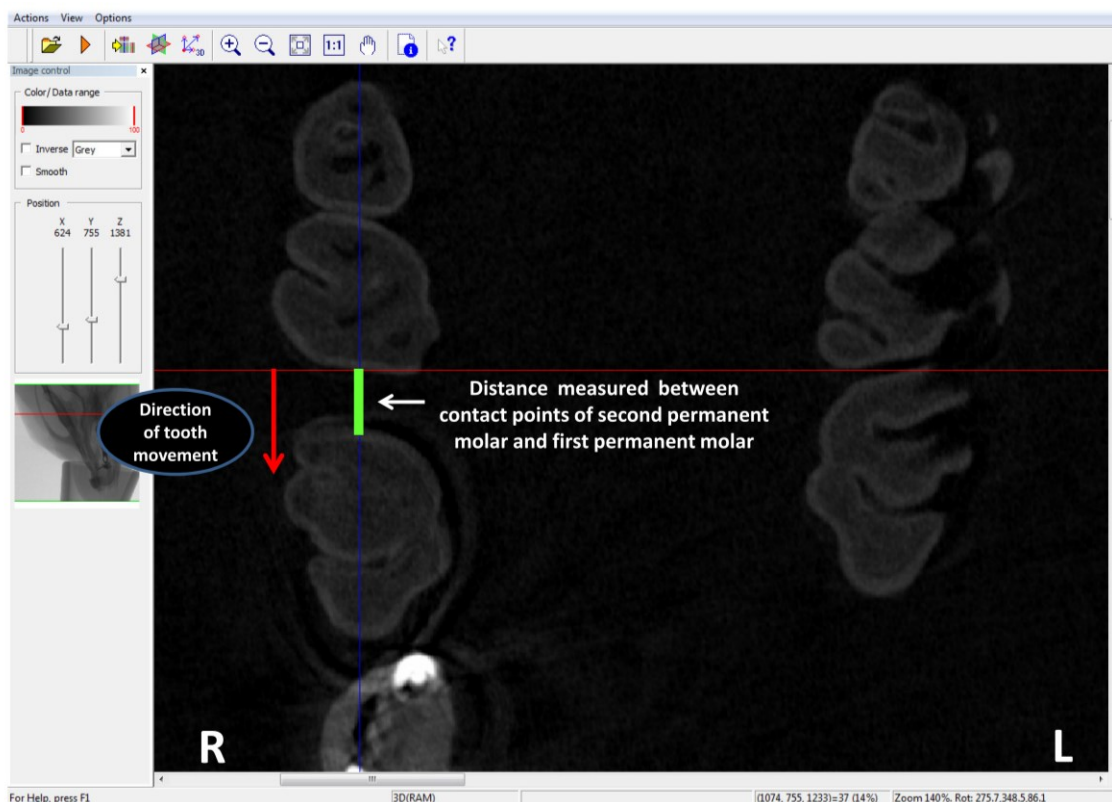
Image of μ CT rendered 2D scan viewed with Data Viewer software for measuring tooth movement. Once the image was centered in three planes of space, the linear distance between the most convex contact area between the upper right second and first permanent molar was measured and recorded at 0, 4 and 8 weeks and the amount of tooth movement was estimated by measuring the difference in tooth movement at 4, 8 weeks compared to baseline (0 weeks)
